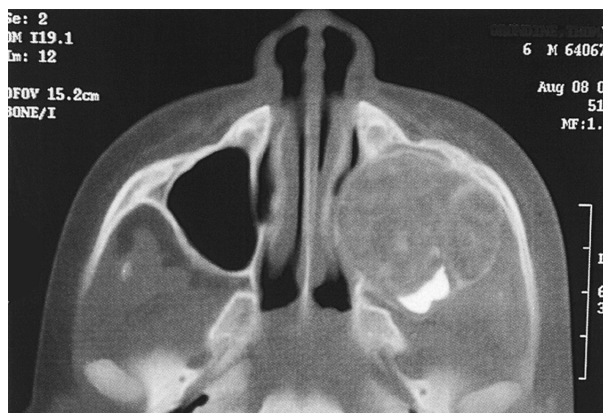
Axial CT image of a juvenile ossifying fibroma of the left maxilla demonstrating bony expansion, obliteration of the maxillary sinus and tooth migration. (from Kaban, Troulis eds. *Pediatric Oral and Maxillofacial Surgery*, Saunders, Philadelphia, 2004, with permission)
